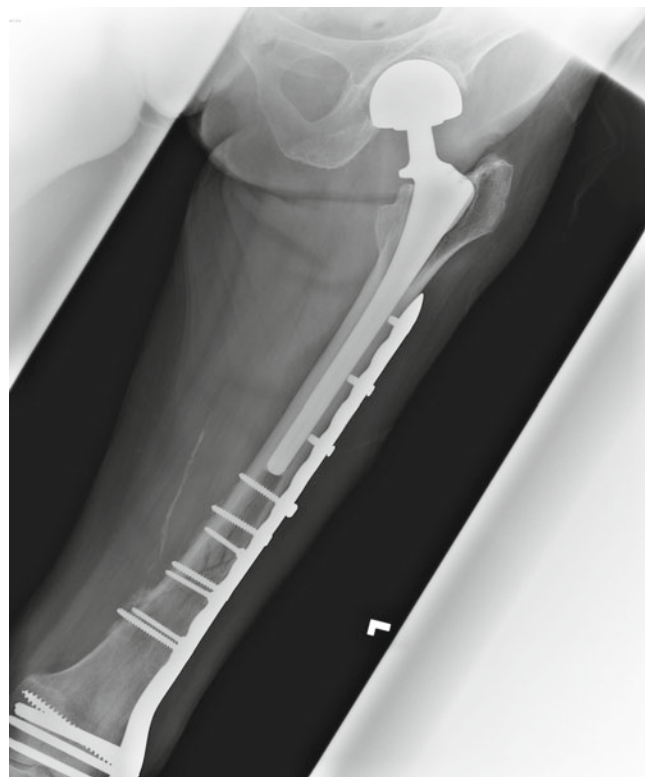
AP femur X-ray of fixation of a periprosthetic fracture
